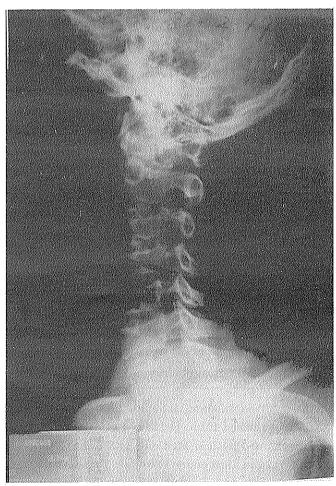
Radiography of cervical spine: lateral view in neutral position
